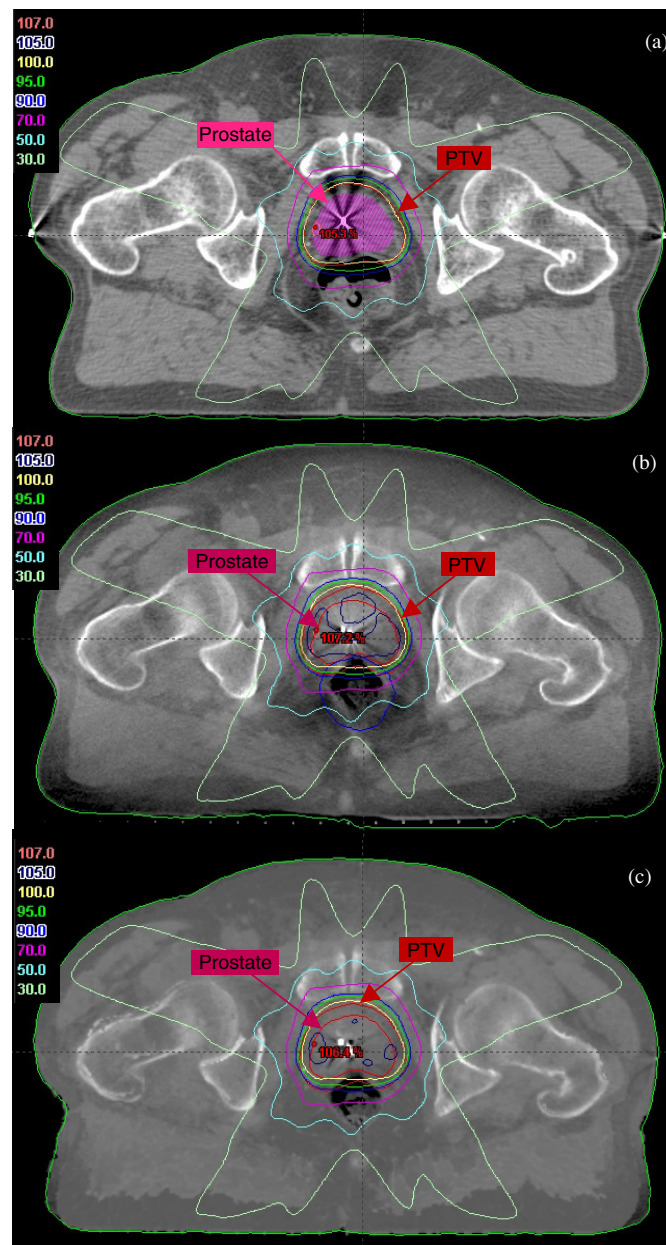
Dose distributions in a transverse slice calculated based on the: (a) pCT; (b) CBCT; (c) mCBCT for the first prostate case. DVHs of the prostate, PTV, rectum and bladder obtained based on the pCT, CBCT and mCBCT images for the case are plotted in (d).
